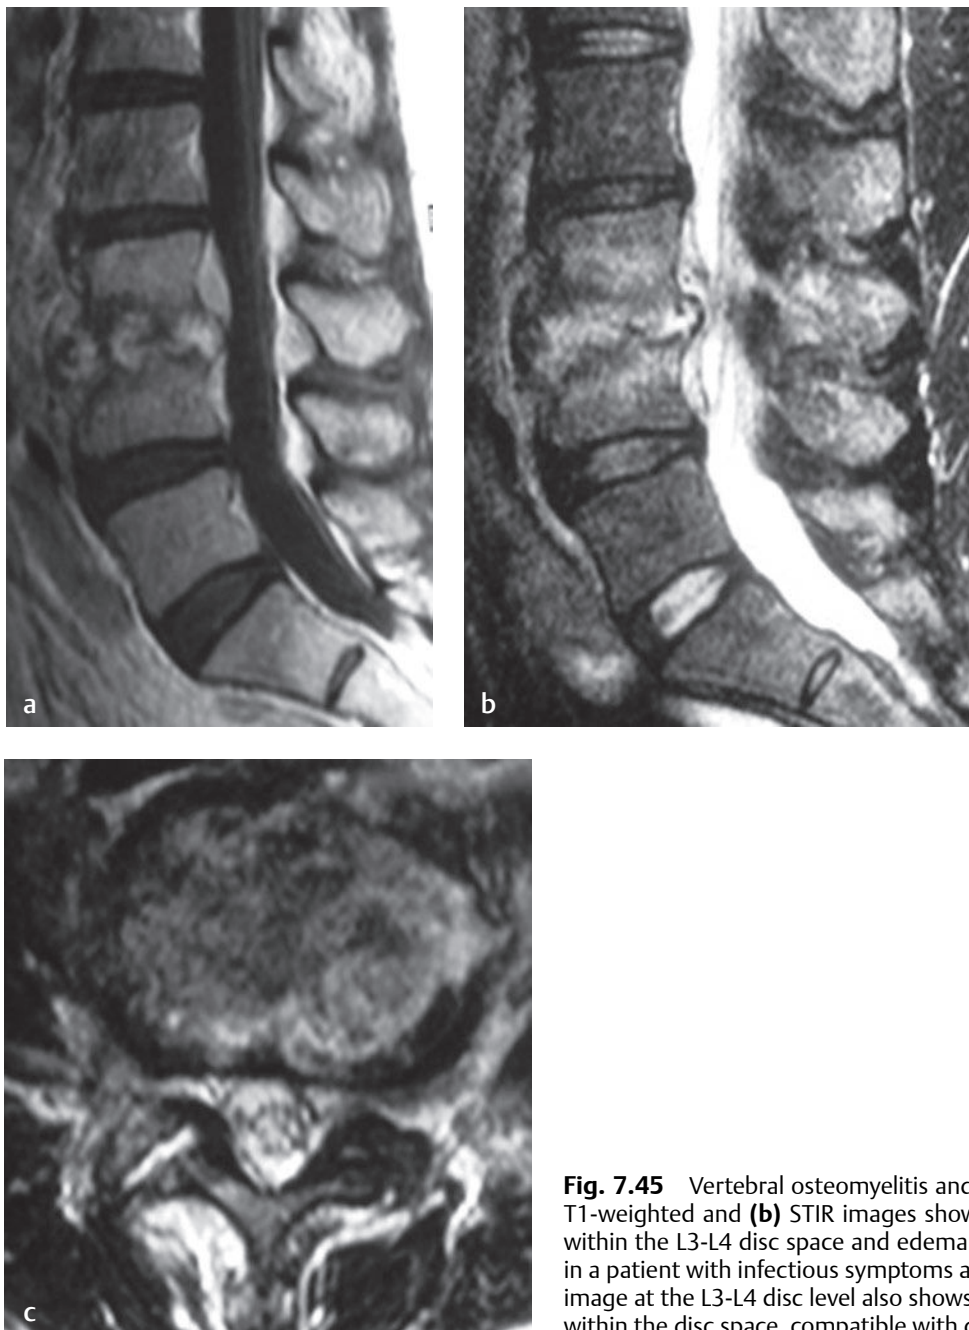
Vertebral osteomyelitis and discitis. (a) Sagittal postgadolinium T1-weighted and (b) STIR images show enhancement and increased signal within the L3-L4 disc space and edema within the adjacent vertebral bodies in a patient with infectious symptoms and findings. (c) An axial T2-weighted image at the L3-L4 disc level also shows heterogeneous and increased signal within the disc space, compatible with discitis.[†]
